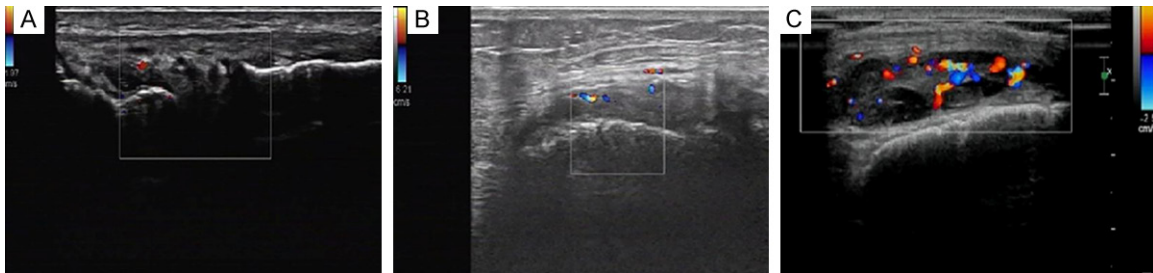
MSUS images of KOA. A. Degenerative lesions of meniscus; B. Synovial hyperplasia; C. Patellar bursal effusion with hyperplasia. KOA: knee osteoarthritis; MSUS: musculoskeletal ultrasound.
